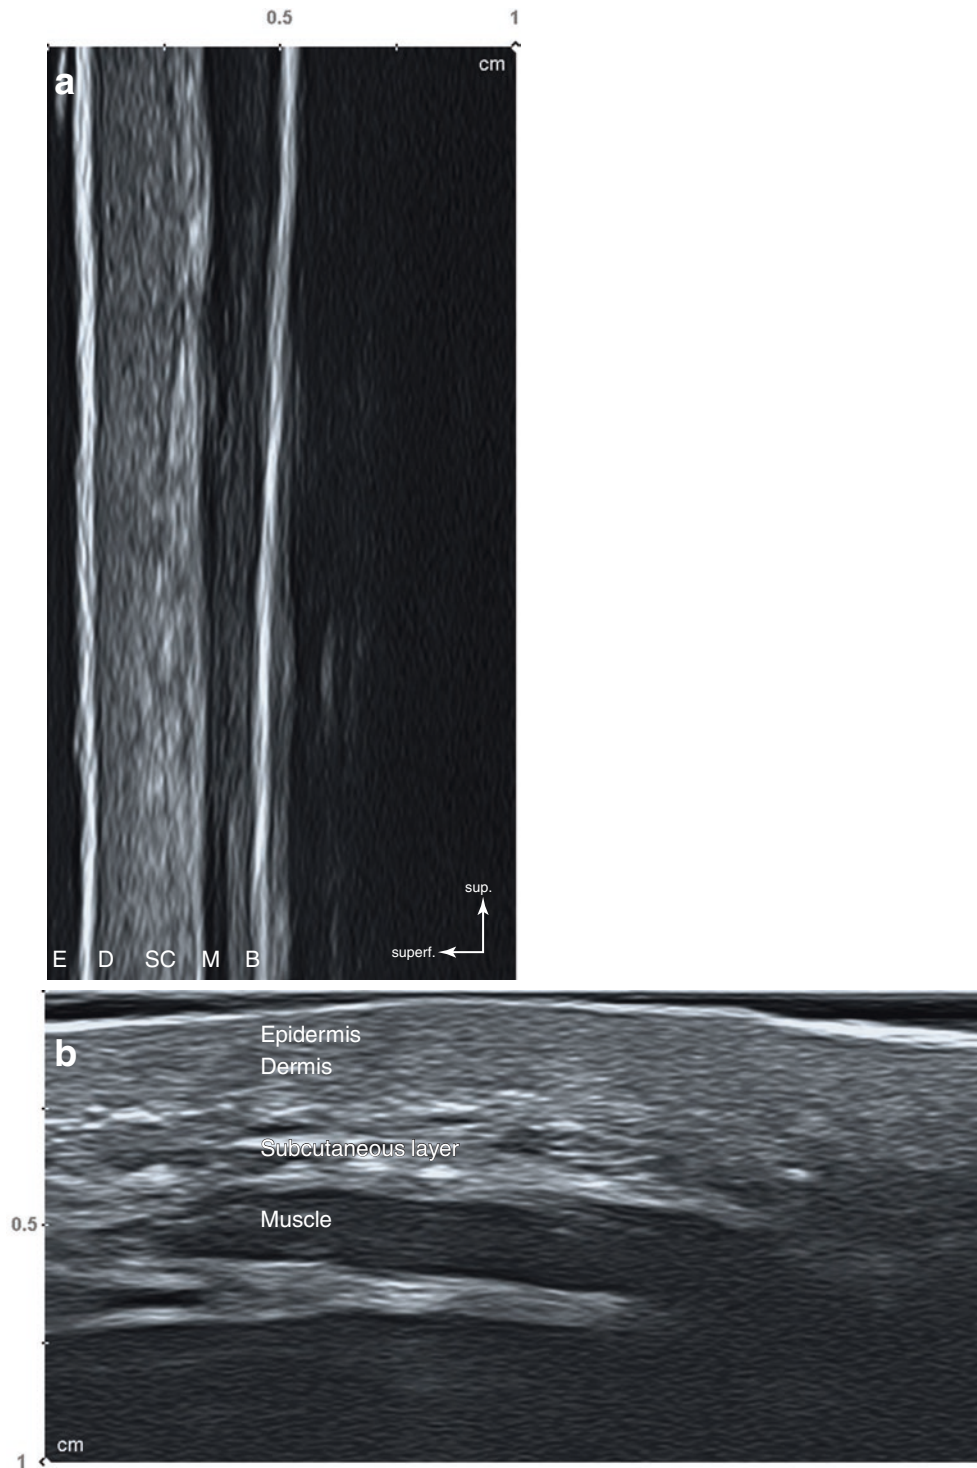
Ultrasonography representing the regional difference of the epidermis (E), dermis (D), subcutaneous tissue (SC), muscle (M), and bone (B). (a) Radix (sagittal view, 24 MHz by linear transducer) and (b)
